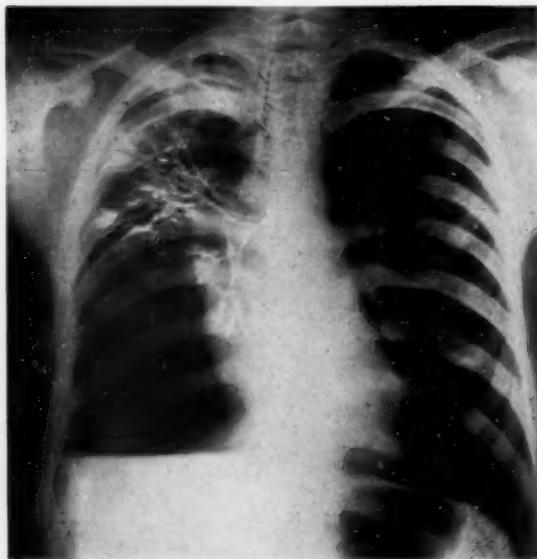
Case VI. Bronchogram outlines a large annular shadow within which is a lipiodol level situated in the second interspace immediately beneath the pleura. While cavitation was thought to be present in the plain film in the first interspace none was suspected in location outlined by the lipiodol.
